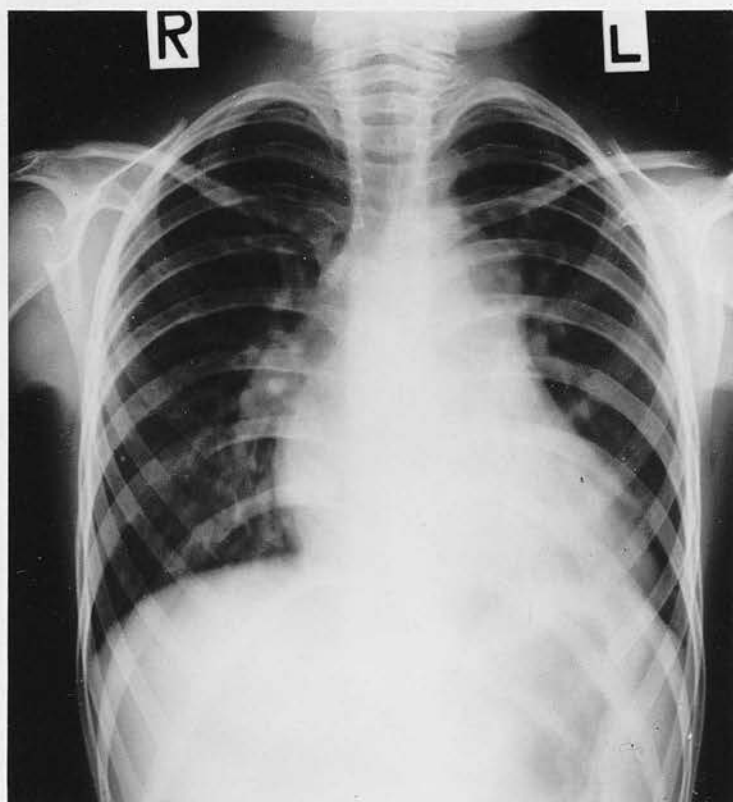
Radiograph of Case 39. Patent Ductus Arteriosus with Pulmonary Endarteritis aged 7yrs.
